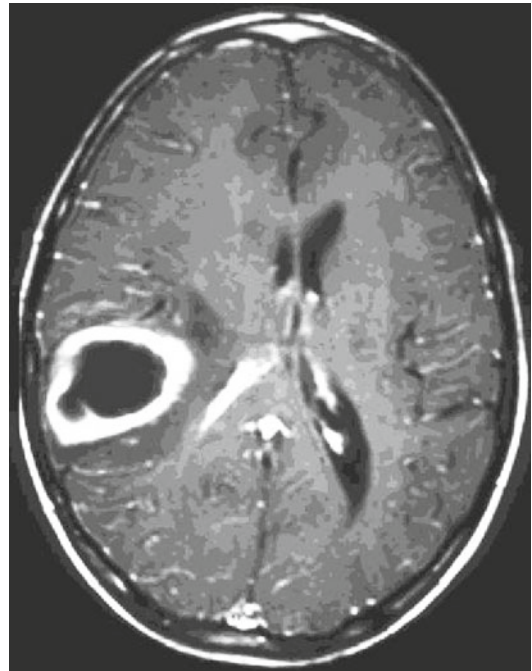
T1-weighted MRI with contrast demonstrating a ring-enhancing lesion suspicious for intracranial abscess
